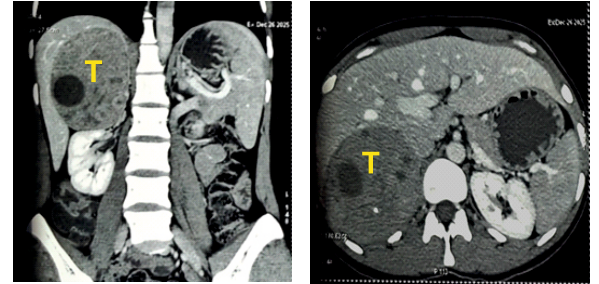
Contrast-enhanced computed tomography (CECT) of the abdomen and coronal and axial view demonstrating a large right suprarenal heterogeneous tumor (T) displacing liver and right kidney with maintained fat planes.
